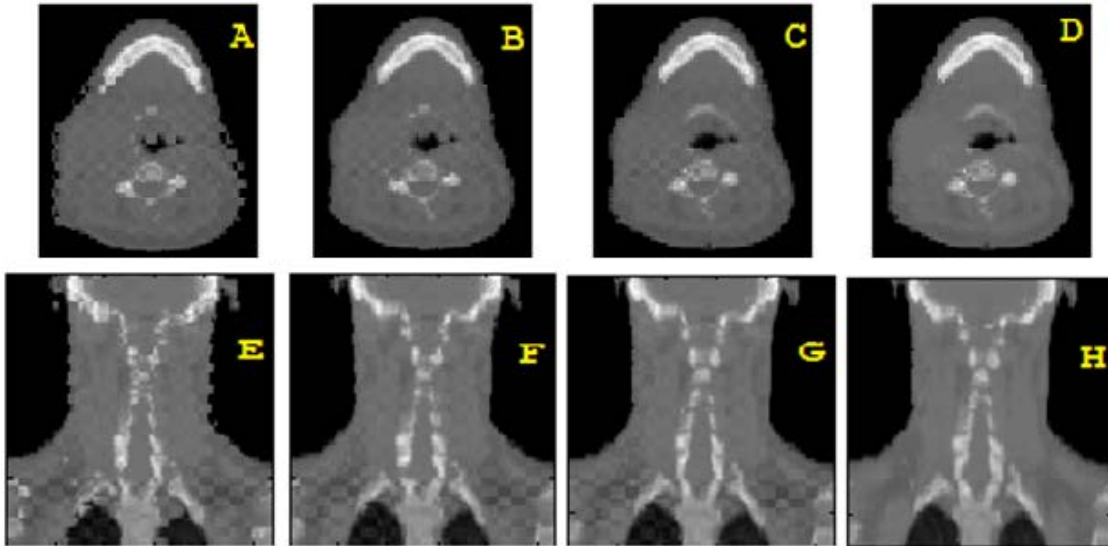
Checkerboard mid axial (top row) and mid sagittal (bottom row) slice of the CBCT and, rigid registration (A, E), IT Demons (B, F), LDIR (C, G), and intensity corrected CBCT with LDIR (D, H).
